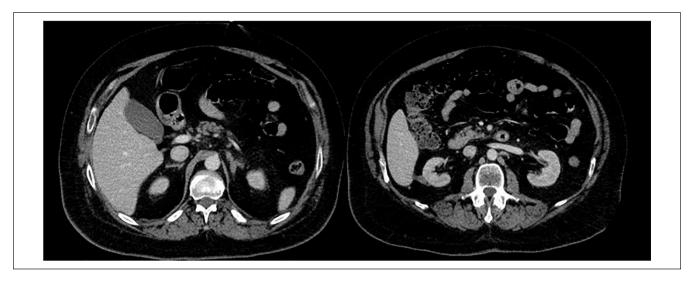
Computed tomography abdomen with contrast, 3 months post-chemotherapy. Resolution of previously noted masses and lymphadenopathy.
